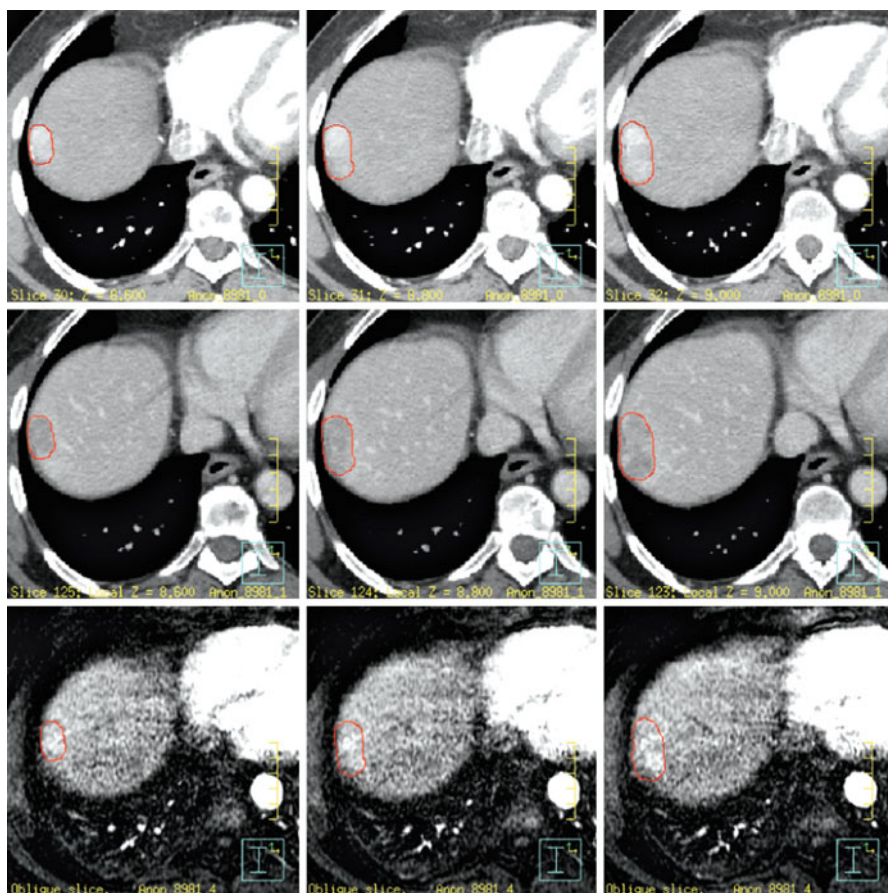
Recurrent HCC post-liver transplant. Multiphase CT and MR obtained in exhale breath hold. GTV shown (in red) has typical enhancement on arterial-phase CT (first row), with washout on venous phase CT (second row). A fused arterial-phase T1 MR shown in the third row. Contouring and recording dose to the chest wall and ribs is optional but should be considered for lesions adjacent to the chest wall, especially if using SBRT
